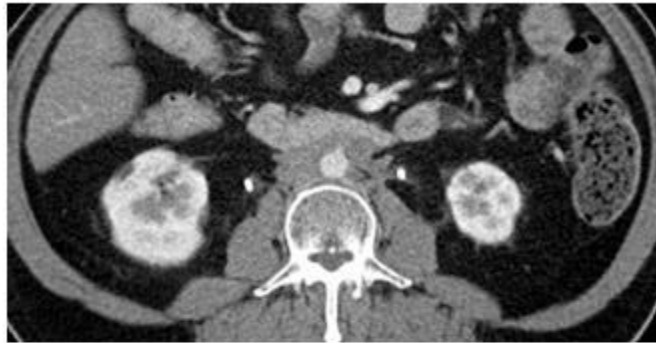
Retroperitoneal fibrosis. Computed tomographic scan of the abdomen reveals an inflammatory mass surrounding the abdominal aorta.
